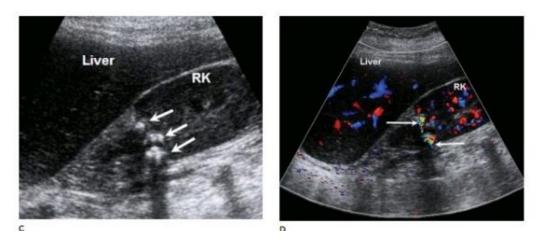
sonographic appearance of renal stones in B mode (left) and Doppler (right) (Diane M, 2012).
